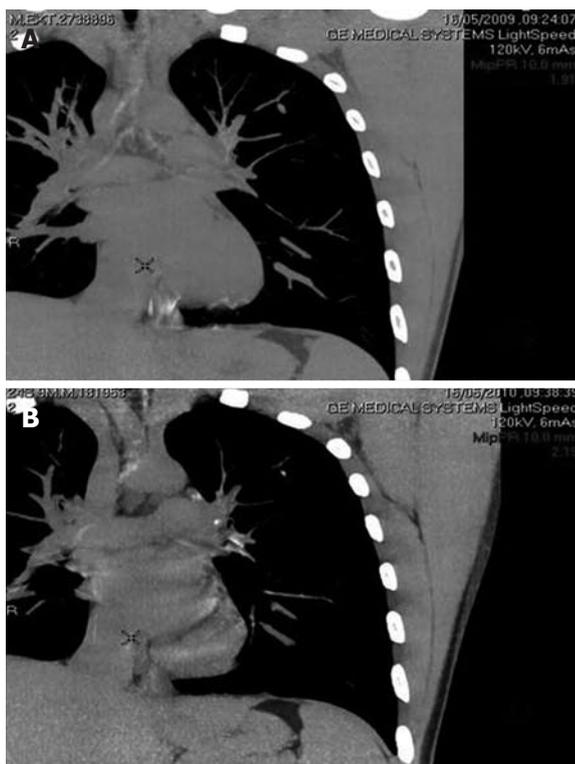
Chest computed tomography. A: Small nodule, measuring 0.8 to 0.6 cm, in the upper lobe of the left lung; B: Small calcified nodule located in the apico-posterior lobe of the left lung, measuring 0.5 cm in diameter.
